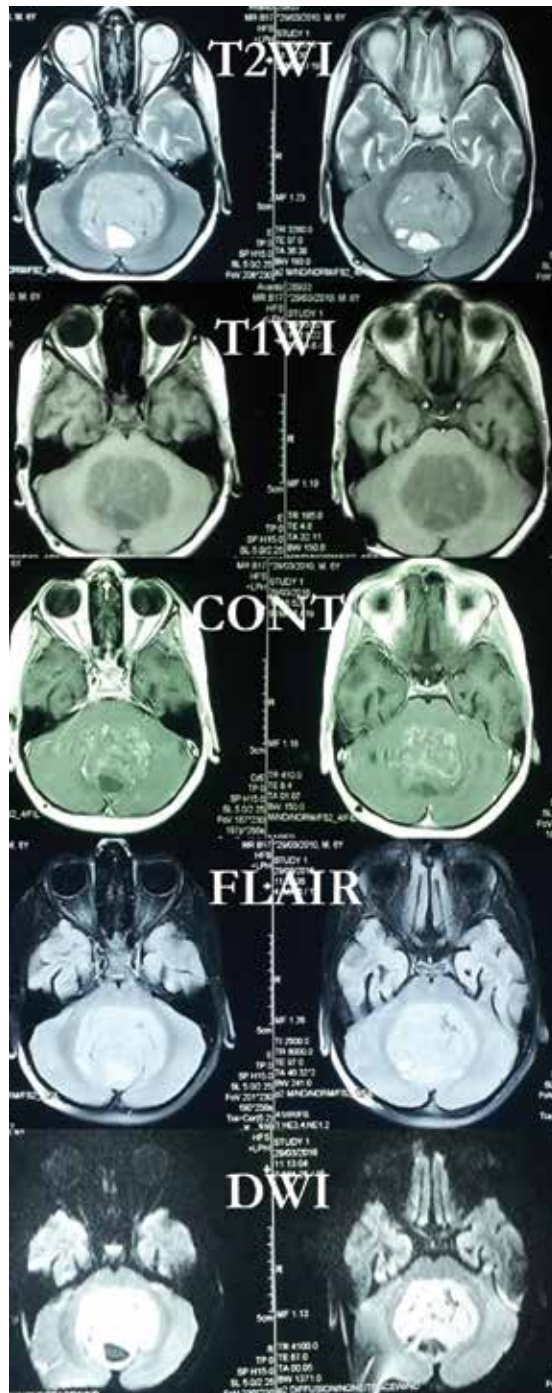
Medulloblastomas in T2-weighted imaging (T2WI), T1-weighted imaging (T1WI), with gadolinium enhancement (CONT), fluid-attenuated inversion recovery (FLAIR) (D) and diffusion-weighted imaging (DWI) in axial planes.
